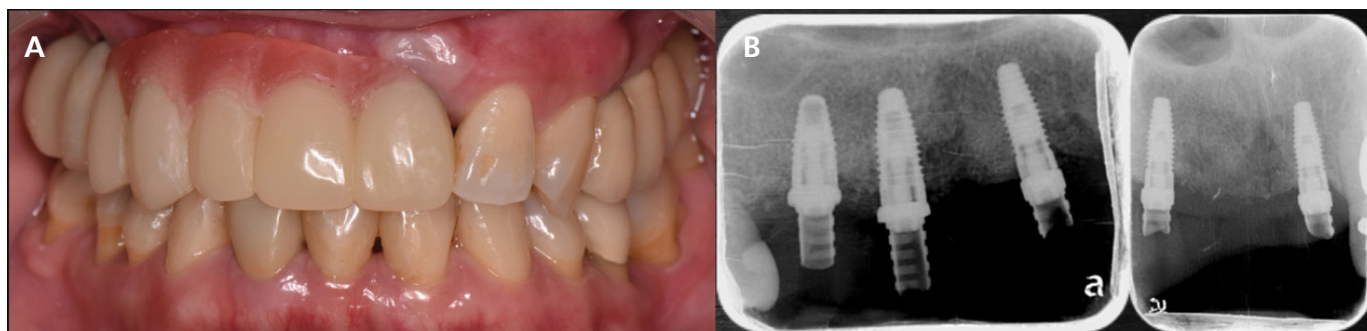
The frontal view after temporary implant supported FDPs delivery. (a) frontal intraoral view; (b) periapical film
